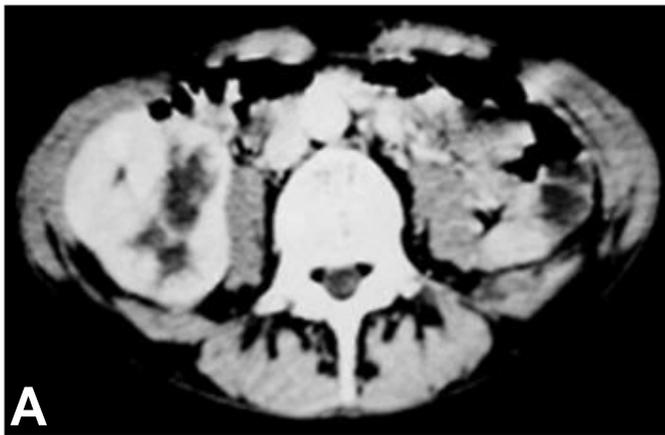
A&B. CT scan of the kidneys showing a heterogeneous mass in the lower pole of the right kidney (A) and two cysts in the left kidney (B).
